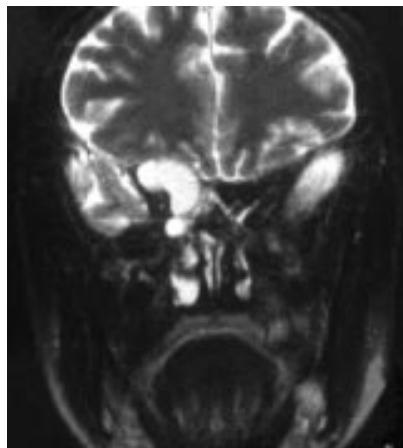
Coronal T2 weighted magnetic resonance image of the orbit showing a mass which compressed the optic nerve superomedially.
